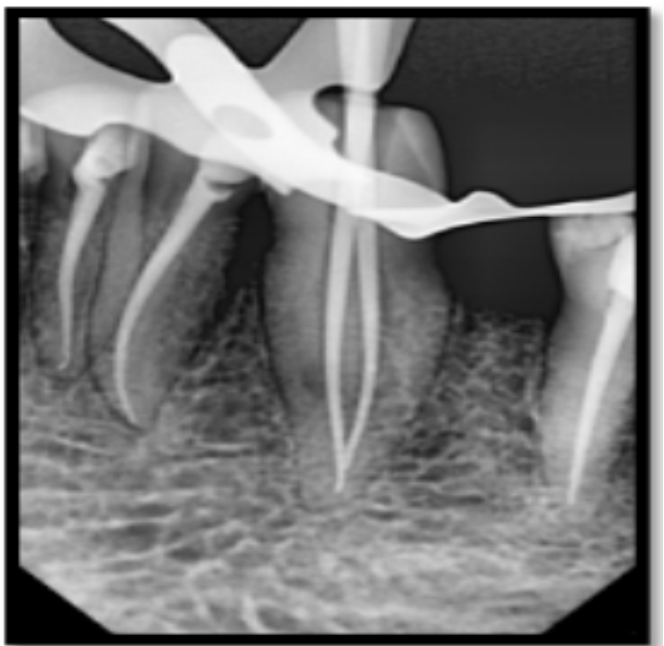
Master Cone Radiograph
